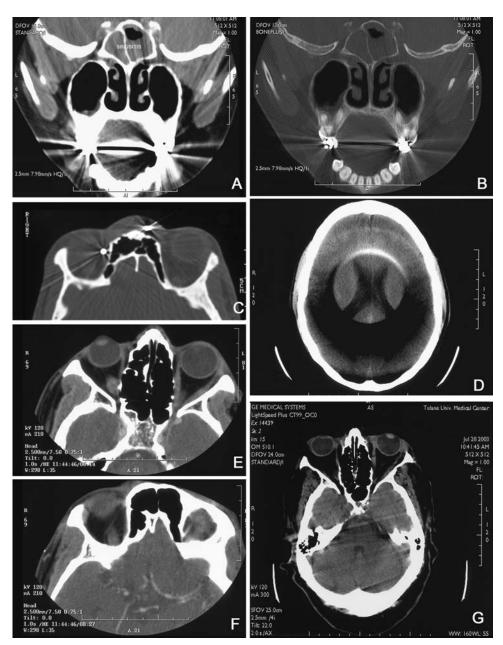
CT artifacts. (A) Dental fillings causing streak artifacts. (B) Artifact in the patient shown in (A) is reduced in bone windows. (C) Shotgun pellets causing streak artifacts. (D) Detector artifact. (E,F) Positioning artifacts. (G) Distortion due to patient motion.
